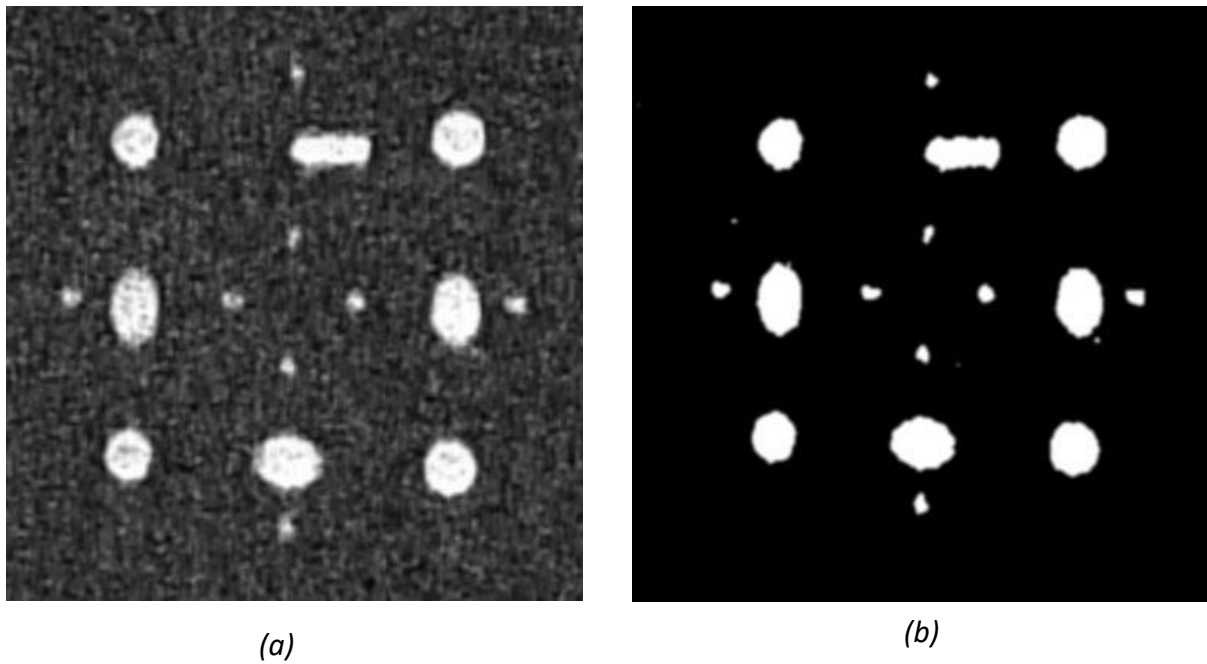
(a) The captured-MR image (T1W) from the Z-frame marker without denoising. (b) The denoised image using the anisotropic filter after binarization. The equation 3.12 was employed for the estimation of the diffusive coefficient.
